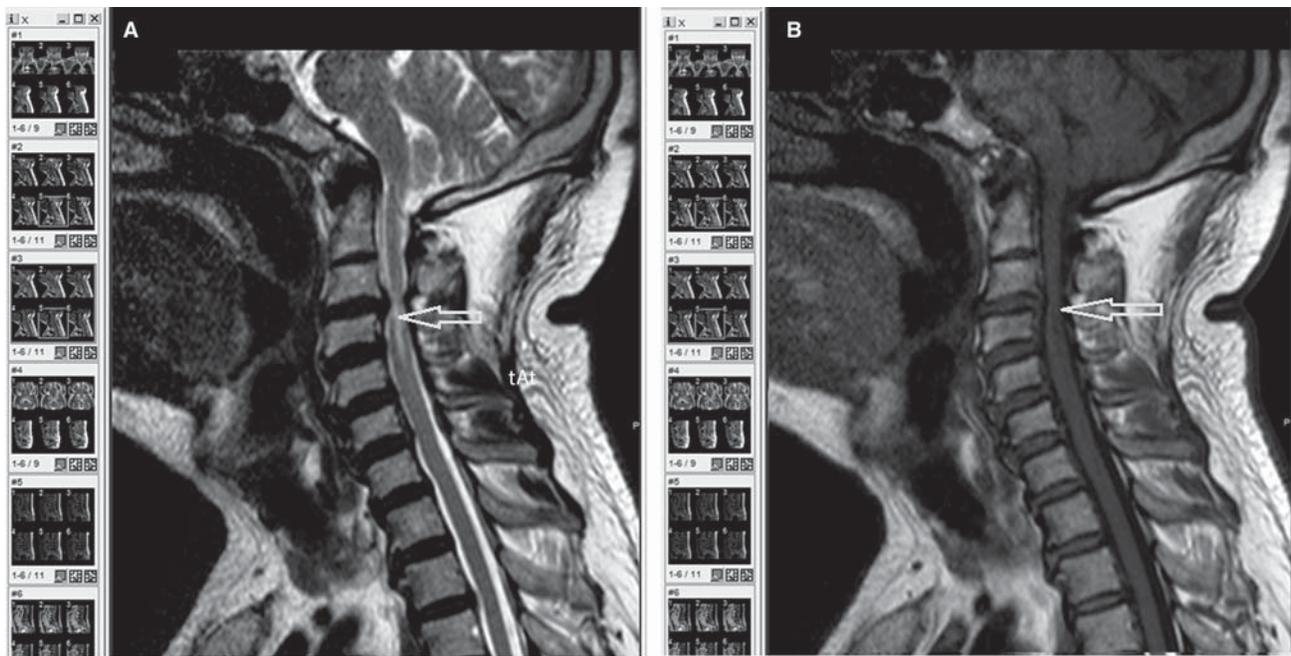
T2-weighted sagittal MRI (A) of the cervical spine with SI changes in the spinal cord as indicated by the white arrow head and T1-weighted sagittal MRI (B) of the cervical with SI changes in the spinal cord as indicated by the arrow head. The appearance of spinal cord SI changes on T1-/T2-weighted sequences was classified into 3 patterns: type 0, normal T1WI/normal T2WI; type 1, normal T1WI/high T2WI; and type 2, low T1WI/high T2WI. Increased or decreased SI was defined on the T2WIs and T1WIs, respectively, as a high-intensity area in relation to the signal of the normal medulla at the unaffected level. MRI indicates magnetic resonance imaging; SI, signal intensity; WI, weighted imaging.
